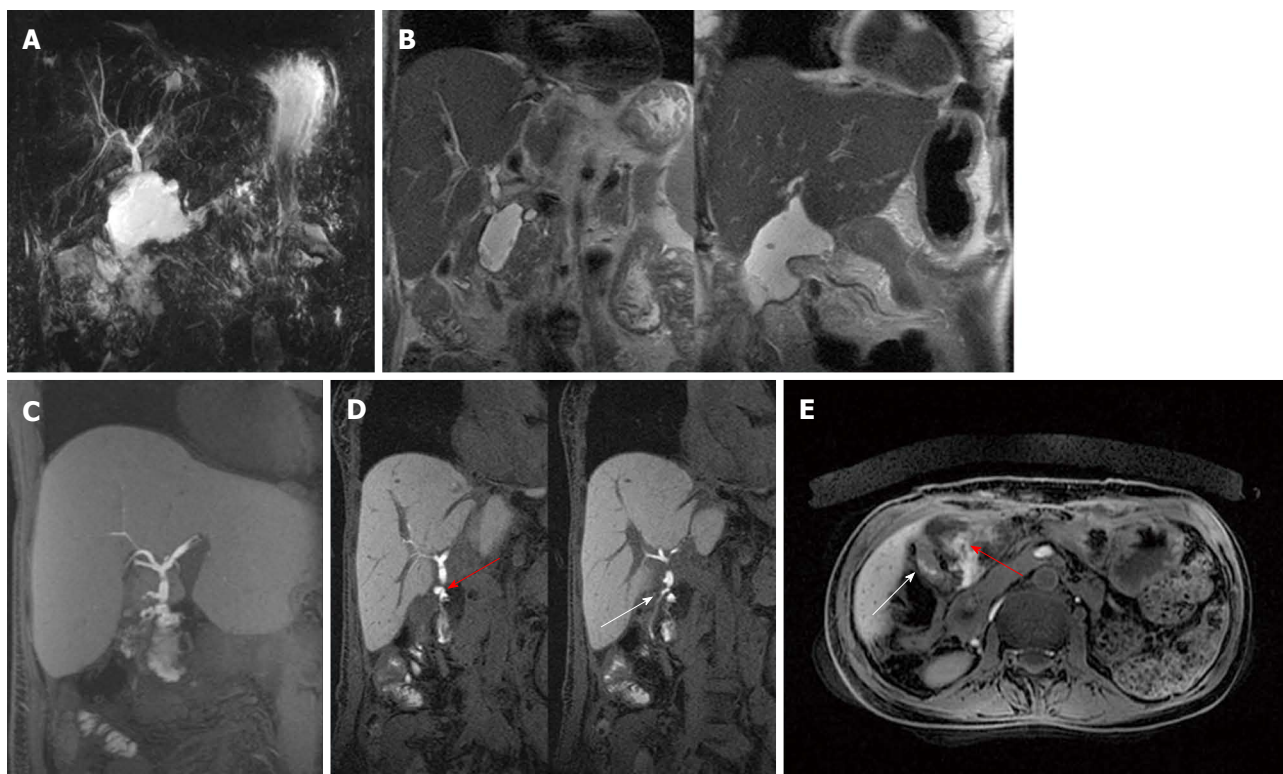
Anastomotic leak in a patient with hepatico-jejunostomy. A: Single-shot thick-slab magnetic resonance cholangiogram shows a fluid collection in the area of biliary-enteric anastomosis; B: Coronal T2-weighted images (at different levels) accurately depict circumscribed sub-hepatic fluid collections with thickened walls. C: Maximum intensity projection reconstruction of Gd-EOB-DTPA enhanced LAVA T1-weighted sequence well exhibits extravasation of contrast material into the peri-anastomotic space compatible with bile leak; D: Coronal Gd-EOB-DTPA enhanced LAVA T1-weighted images better identify contrast agent both extravasating from an anastomotic leak (red arrow) and filling the Roux-en-Y anastomosis (white arrow); E: On axial post-contrast LAVA image it is possible to distinguish the fluid collection (red arrow) from the jejunum (white arrow).
